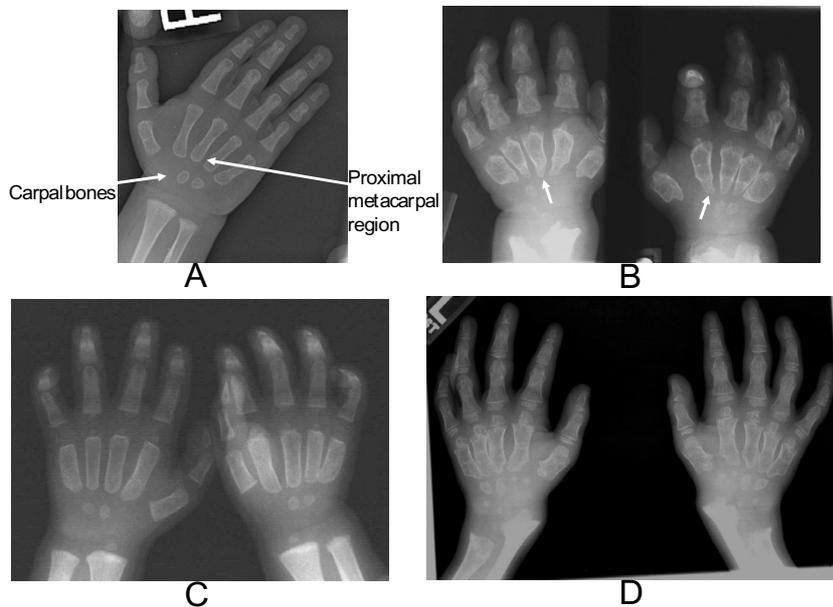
Manifestations of dysostosis multiplex in the hands. Radiographs showing (A) a normal hand with arrows showing the regions that can be most severely affected in MPS, and the hands of MPS patients in (B) late infancy, with very severe proximal pointing, wide (expanded) short metacarpals and phalanges, and thin cortices (arrows), (C) early childhood, with moderately severe proximal pointing, and expanded metacarpals with thin cortices, (D) late childhood, with severe proximal pointing, thin cortices, small/irregular carpal bones, and ulnar hypoplasia.
